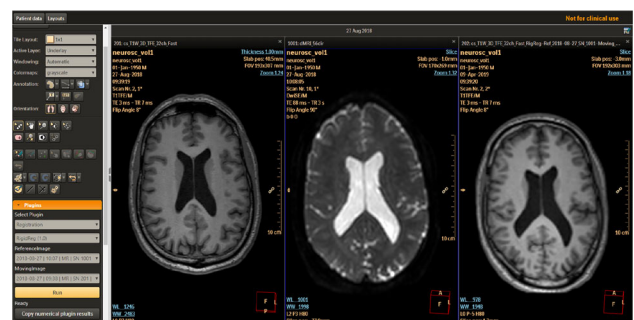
Rigid registration of T1-weighted anatomical images (left) to diffusion MRI data (center), and the transformed data (right).
